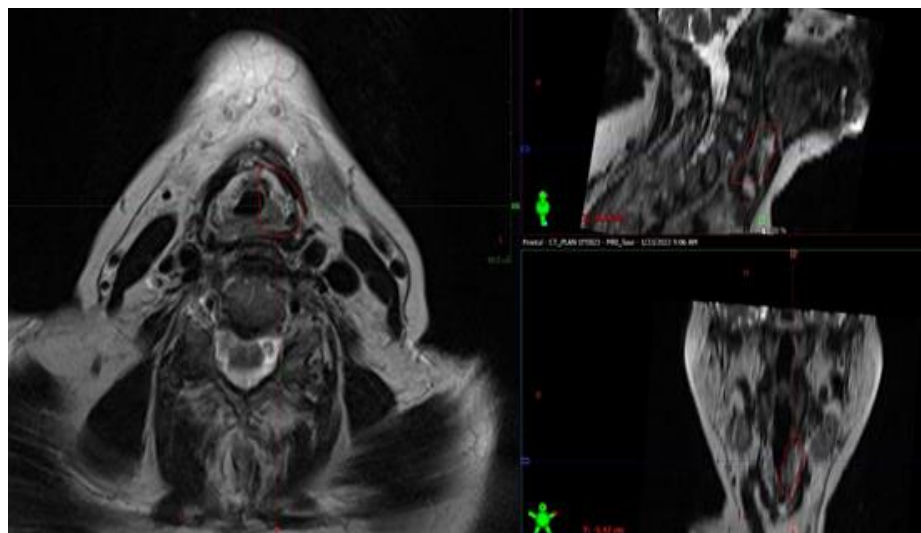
MRI scan of the neck showing slight thickening and irregularity of left side false vocal cord suggestive of the residual lesion with no significant enlarged cervical lymphadenopathy.
